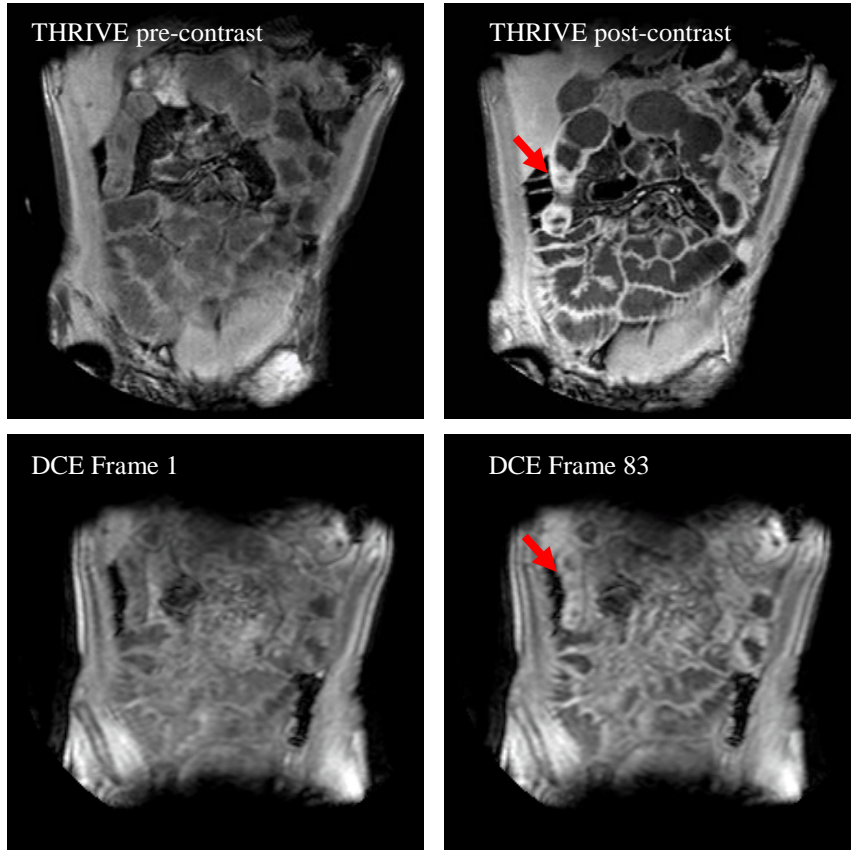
Typical example of THRIVE and DCE-MRI. TOP LEFT: 2D slice of a pre-contrast THRIVE scan in our dataset. TOP RIGHT: Corresponding post-contrast THRIVE slice after DCE-MRI (during DCE-MRI, a contrast agent is applied to the patient). CD affected regions show a slightly enhanced signal, as indicated by the red arrow. BOTTOM: Two registered 2D slices of the DCE sequence of the same patient (time frames 1 and 83). 450 such frames are shot during six minutes. The spatial resolution of DCE-MRI is much smaller than of THRIVE.
